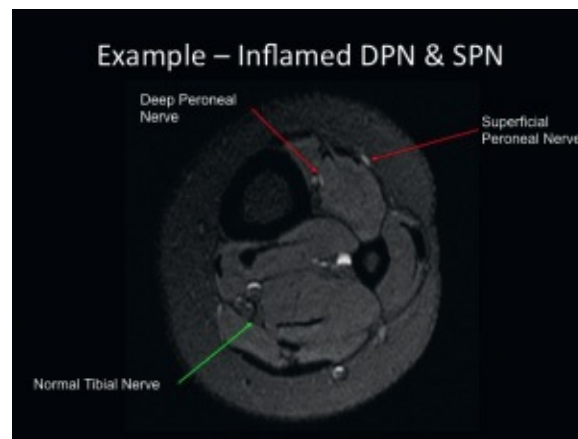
• MRI showing inflamed deep peroneal nerve and superficial peroneal nerve.
